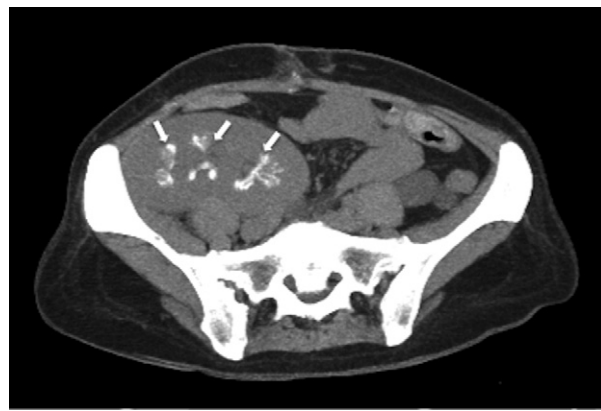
Unenhanced CT image shows multiple pyramidal calcifications in the transplanted kidney (arrows). This image was recorded one month after that showed in [Figure 1](#).
